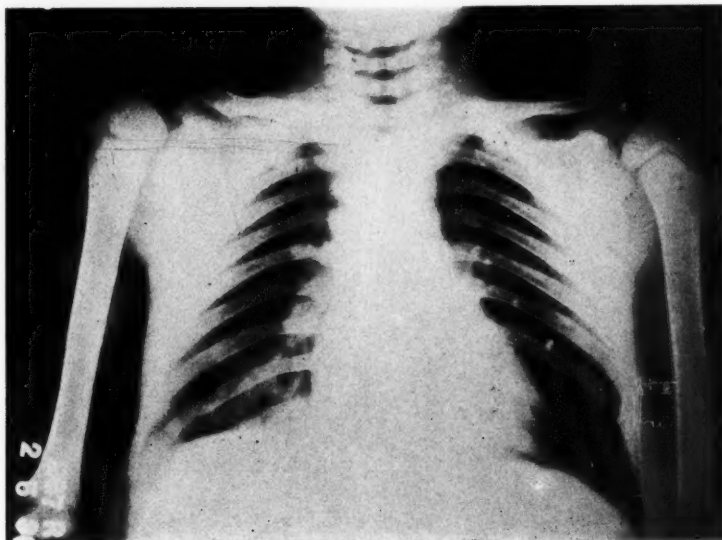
Roentgenogram of the shoulders. Note normal clavicles, acromial defects, absence of coracoid processes, and failure of union in the cervical vertebrae.
